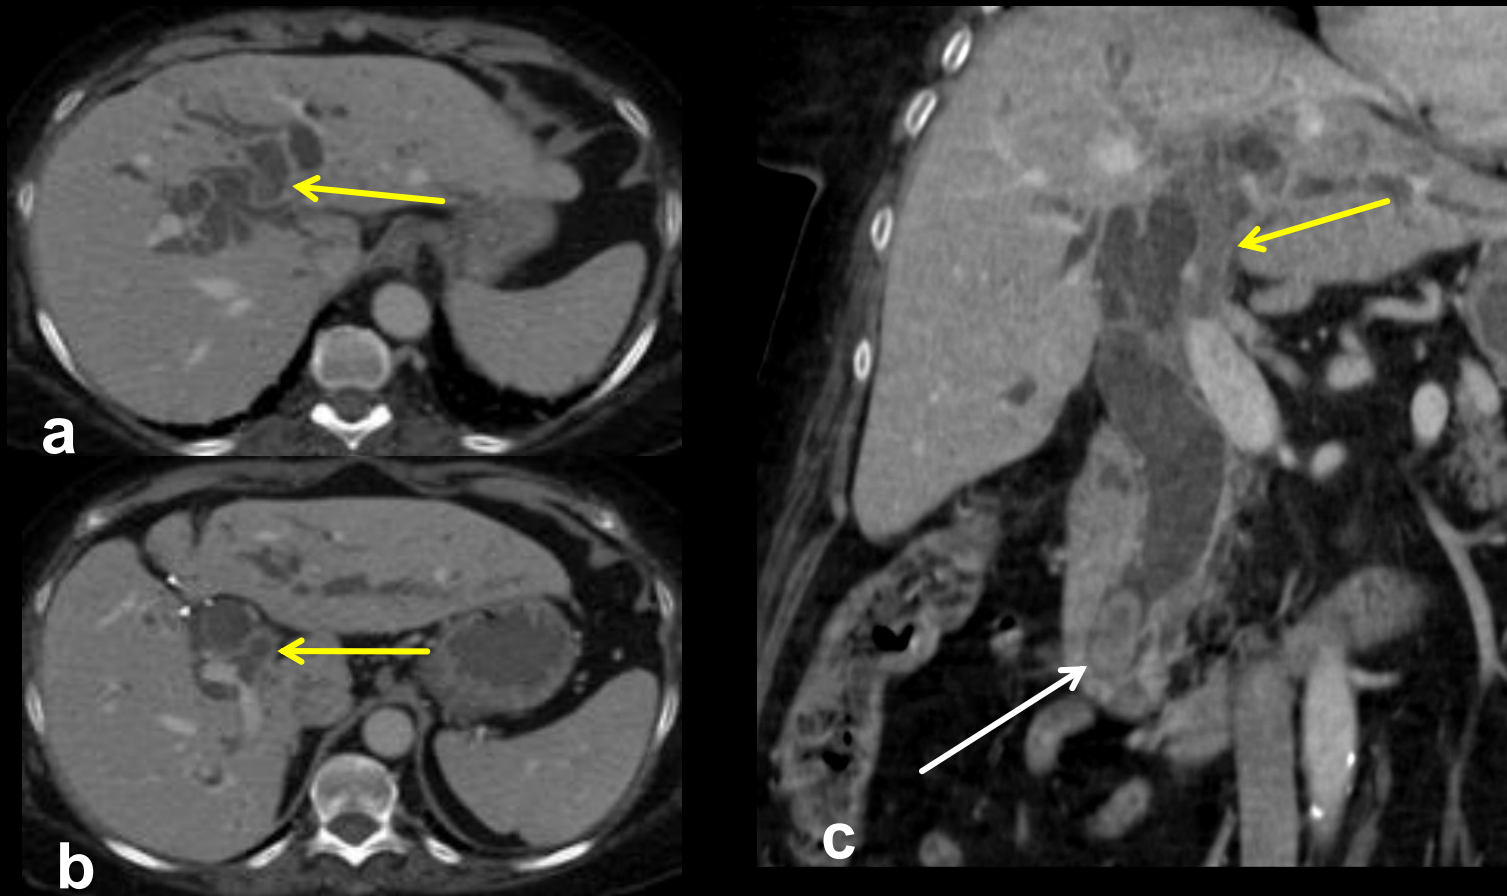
Transverse (a,b) and coronal (c) CT images of a patient with cholangitis secondary to choledocholithiasis (white arrow). There is complication with septic thrombosis of portal vein and its left branch, showing thickened walls (yellow arrows).
